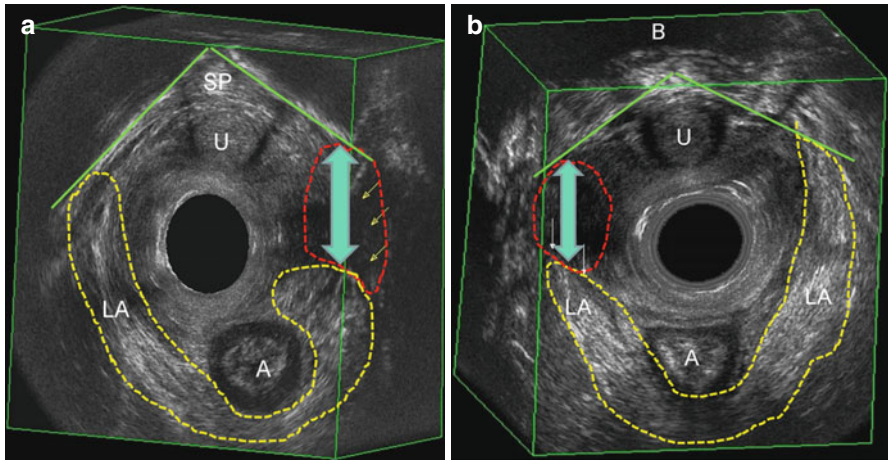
3D endovaginal ultrasound. Levator ani (LA) (arrows) avulsion from the left inferior pubic rami in (a) and from the right inferior pubic rami in (b). A Anal canal, B bladder, SP symphysis pubis, U urethra
